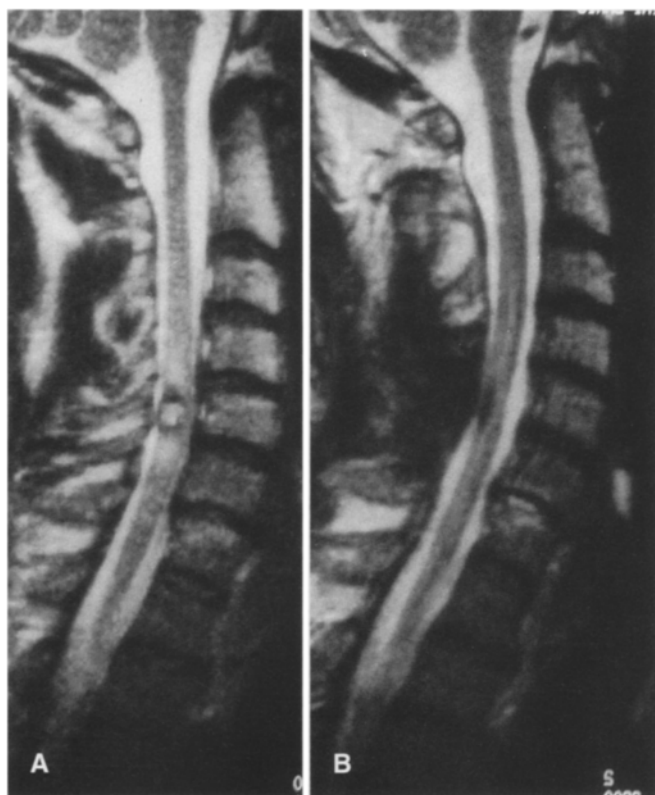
A Preoperative and B postoperative T2-weighted MR images of a cervical intramedullary cavernous angioma
